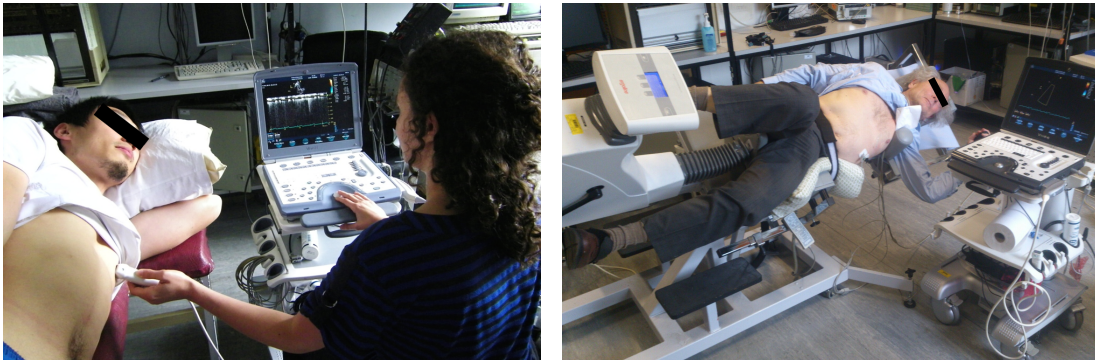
Echocardiography measurement of an participant. A. Echocardiography measurement. The participant remained in a left lateral recumbent position. The echocardiography operator sat next to the participant to acquire data; B. Stress echocardiography measurement. The participant remained in a left lateral recumbent position on a stress echocardiography ergometer. The participant's left hand, wrist, hip and head were fixed to stabilise the body during exercise.
